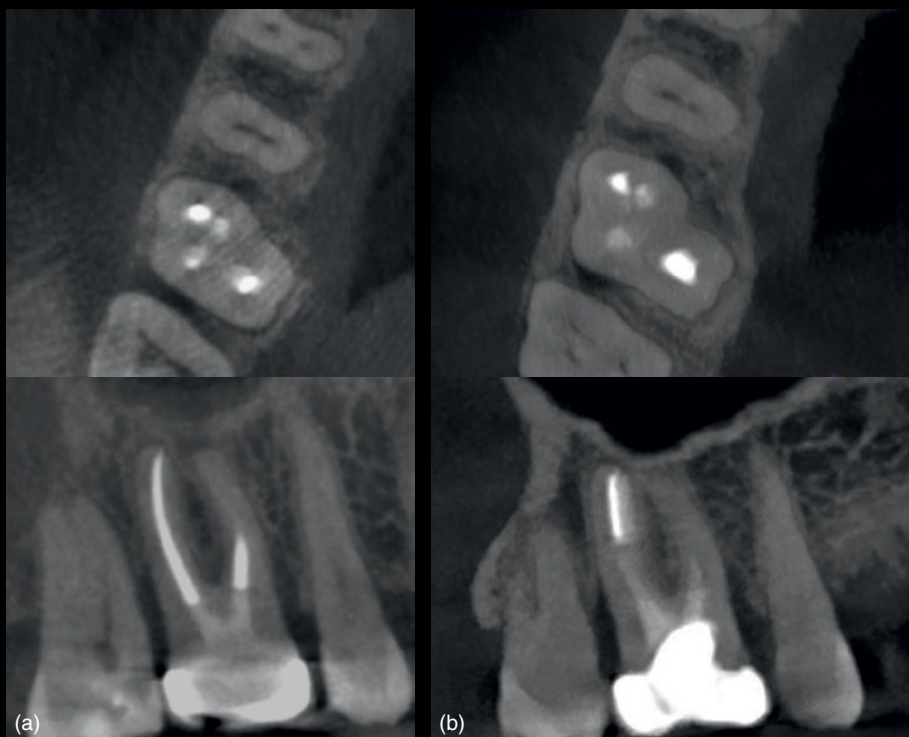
Cone beam computed tomography axial and sagittal views of an upper right first molar (UR6) exhibiting cracks with radicular extension at both the mesial and distal surfaces. (a) Three-year follow-up images and (b) seven-year follow-up images showing minimal to no change in the appearance of the isolated, narrow periodontal defects over four years.
